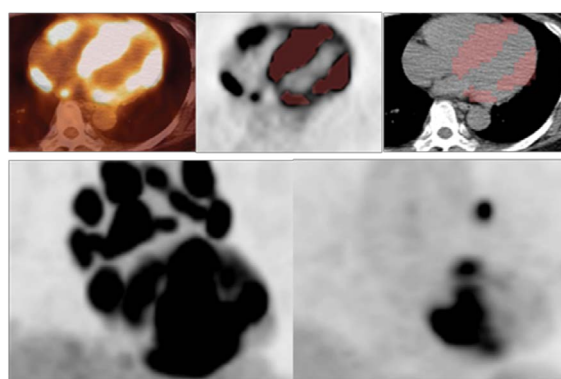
A 54-year-old female who was a non-responder to steroid therapy for CS. From ¹⁸F-FDG PET/CT fusion images before steroid therapy (upper left), the volume of the LV wall with SUV ≥ 4.0 automatically extracted (upper centre) and displayed on the CT images (upper right). The SUVmax, MV and TLG in the LV wall before therapy are 17.6, 245 cm³ and 1776 g, respectively. Maximum-intensity-projection image of ¹⁸F-FDG PET/CT before steroid therapy (lower left) and 8 months after initiation of steroid therapy (lower right) are presented. After steroid therapy, the patient had continually unstable symptoms of heart failure and cardiac dysfunction and additional administration of methotrexate was performed. The post-therapy SUVmax, MV and TLG in the LV wall after steroid therapy are 10.0, 42 cm³ and 282 g, respectively.
